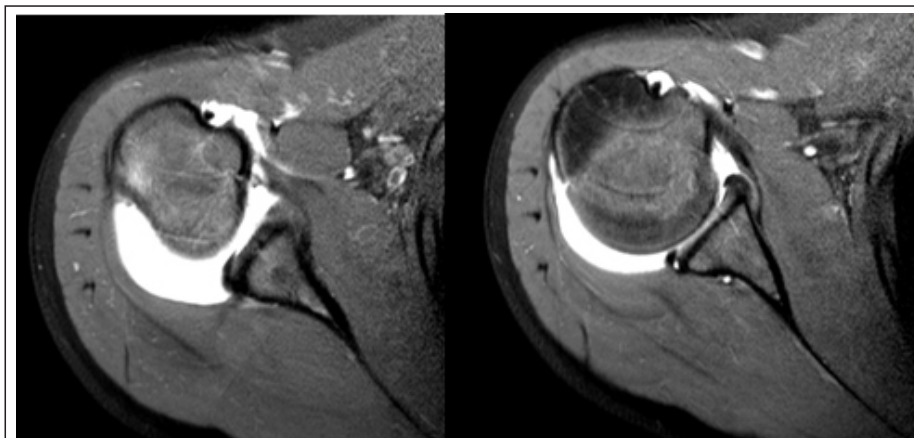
18 years old female affected by shoulder instability. Posterior capsular laxity and degeneration of the posterior labrum are well studied by Arthro-MRI
